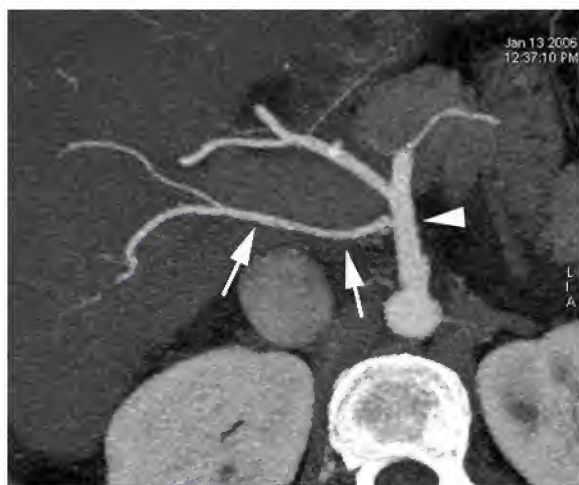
Coronal MIP rendering of CT angiogram shows the common hepatic artery (arrow) originating from the superior mesenteric artery (arrowhead)
